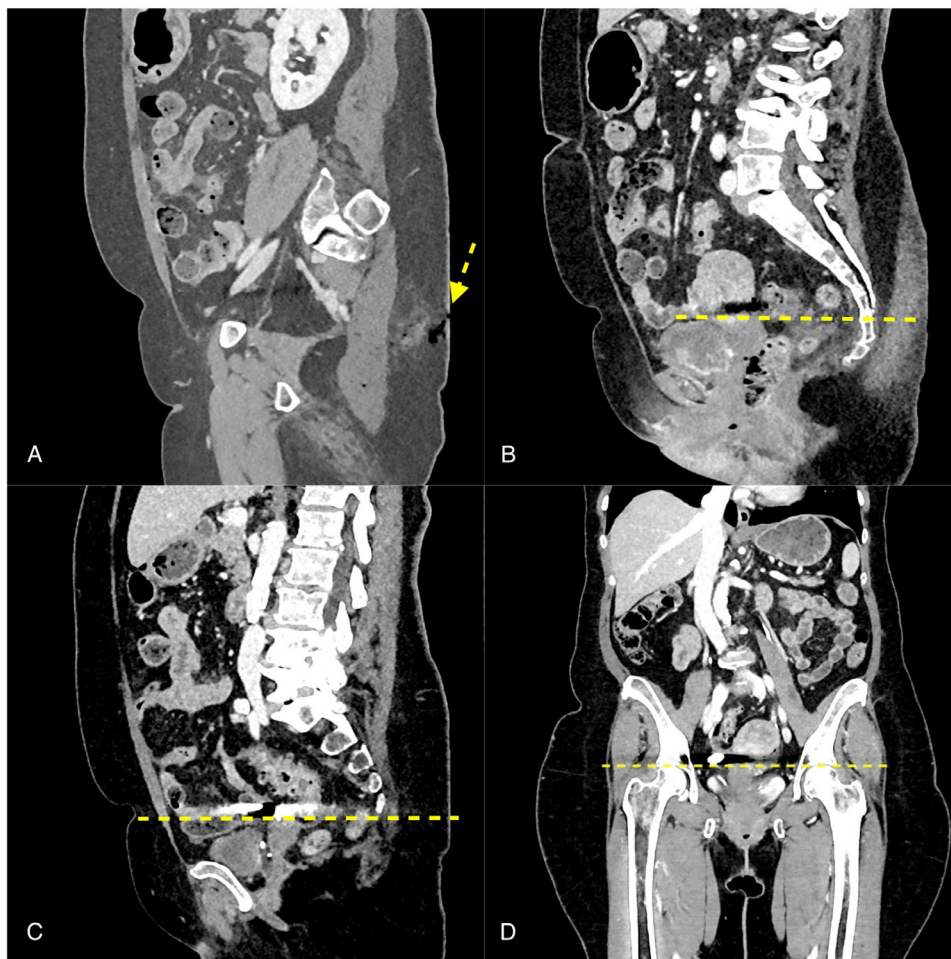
(A-D) Sagittal CT scout show bullet's trajectory analysis and its track (dashed yellow line): (A) the entry wound in the left gluteal region (yellow arrow) and (B, C) its progression through the uterus (dashed yellow line), the sigmoid colon and the ileum (dashed yellow line). (D) Curved coronal MPR view reconstructions of the bullet's trajectory analysis and its track (dashed yellow line).
